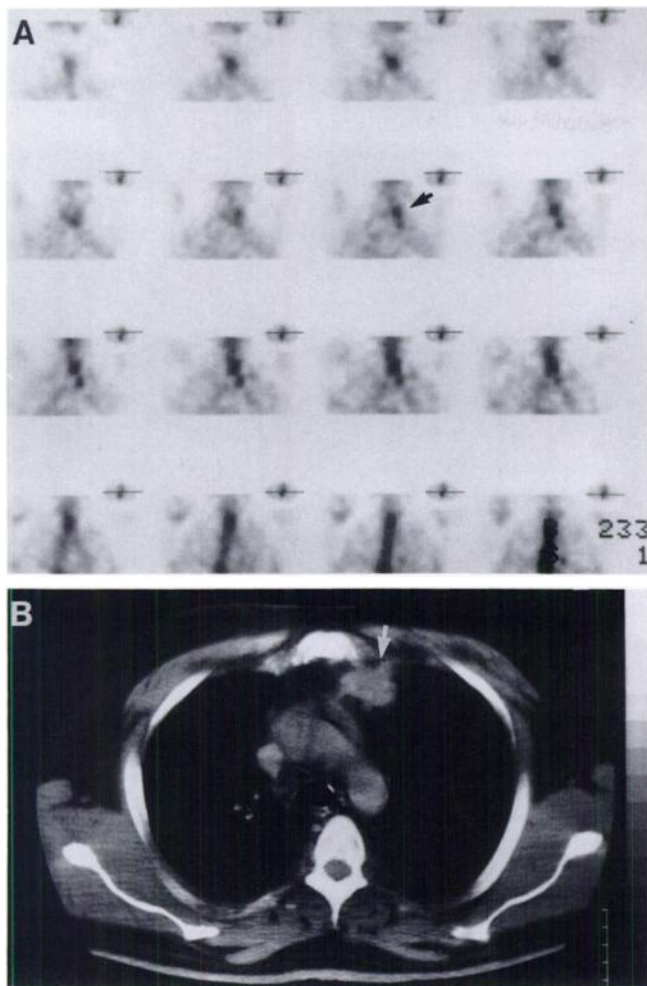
(A) A 30-yr-old male with Hodgkin's disease underwent SPECT imaging for reevaluation of the extent of disease 9 wk following the cessation of treatment. Coronal sections of the SPECT study reveal intense radiotracer uptake in the left paratracheal and hilar regions (arrow) which were all highly suggestive of active disease. (B) CT scan at the same corresponding level as SPECT images shows residual disease with subtle calcification, contained within the left anterior mediastinum (arrow). Biopsy of the mediastinal lymph nodes showed dense sclerotic fibrosis with evidence of old hemorrhage and a few nests of thymic tissue and no evidence of active disease.
